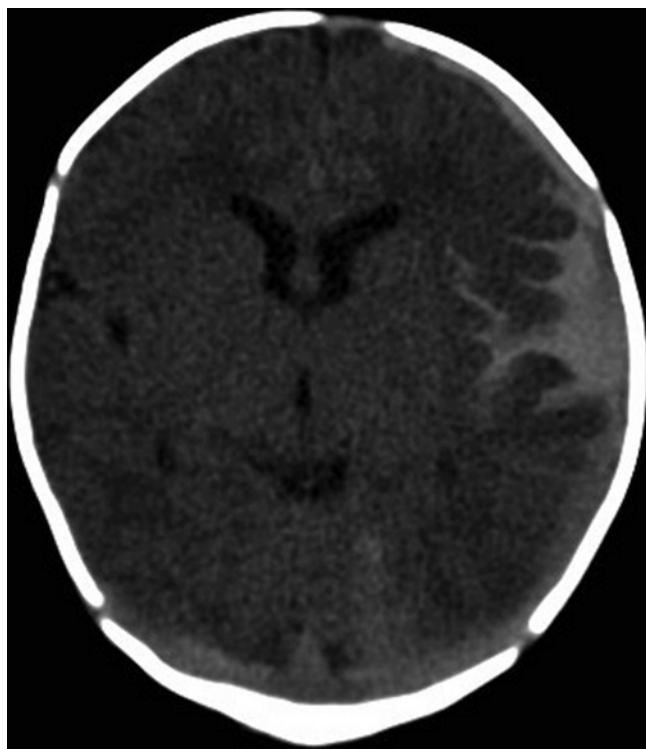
CSVT with hemorrhage. CT, axial view, showing left sided subdural hemorrhage (SDH) and CSVT in the sagittal sinus and bilateral transverse sinuses. Note the slight difference in density between the SDH and CSVT
